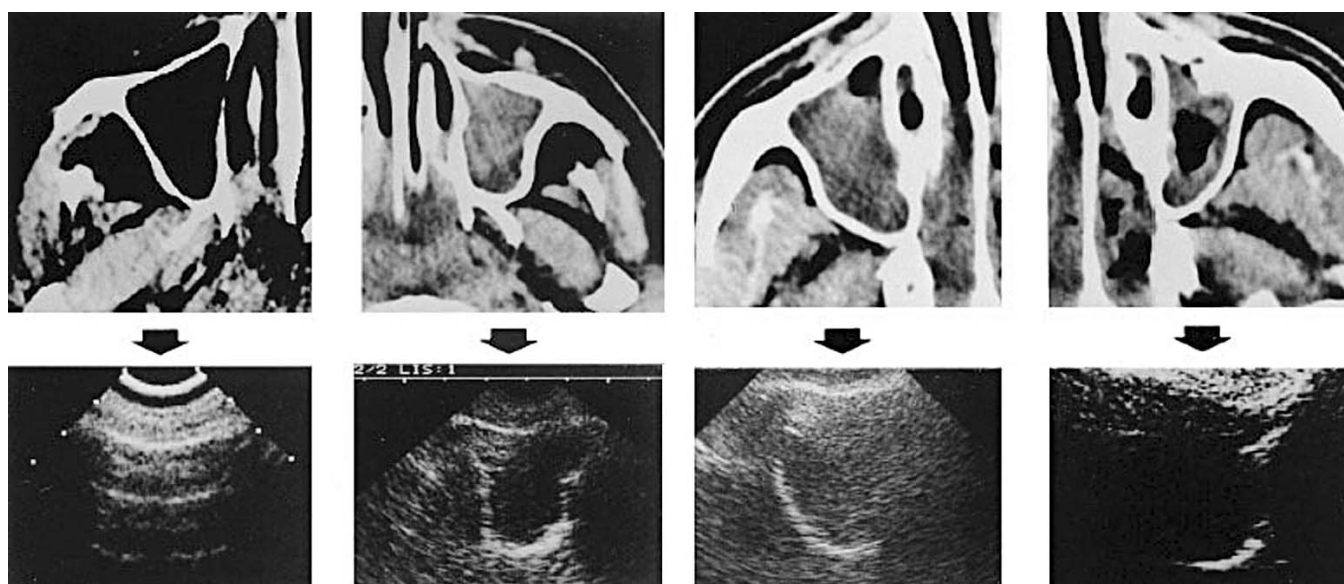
Normal versus pathologic ultrasound pattern. Computed tomography sections of maxillary sinuses are in the upper row with their corresponding ultrasound pattern in the lower row. *From left to right:* normal pattern—total opacity of the left maxillary sinus (the internal, posterior, and external walls of the sinus are visible, giving a complete “sinusogram”); 90% air-fluid level of the right maxillary sinus (the internal wall is not visualized, giving an incomplete “sinusogram”); and mucosal thickening of the left maxillary sinus (the internal wall is not visible and the external wall is ill-defined, giving a partial “sinusogram”). (Reproduced, with permission, from Lichtenstein D, Biderman P, Meziere G, et al. The “sinuso-gram”, a real-time ultrasound sign of maxillary sinusitis. *Intensive Care Med.* 1998;24:1057–1061. With kind permission from Springer Science and Business Media.)
